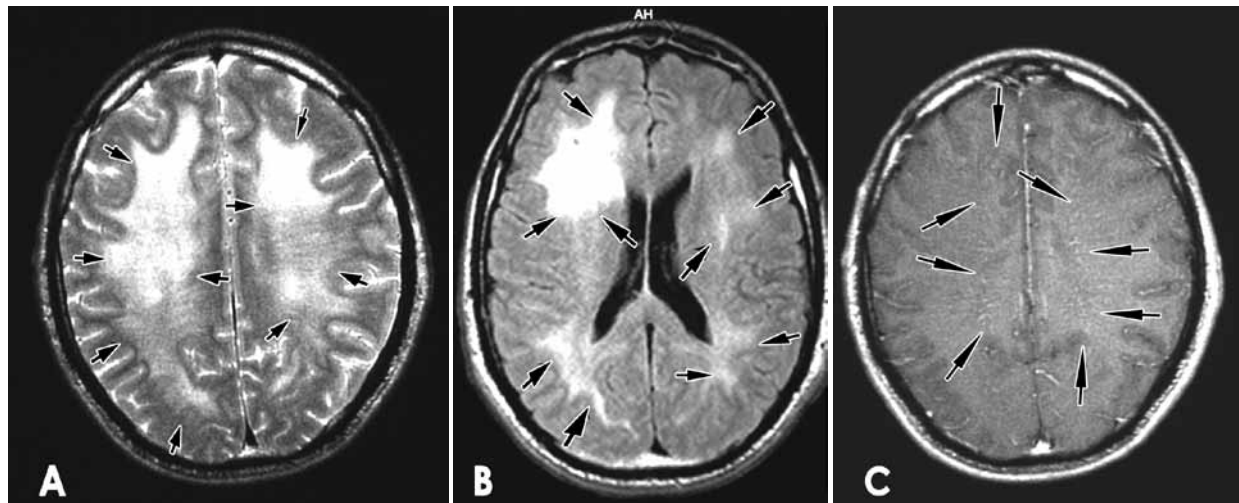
Diffuse white matter signal changes (arrows) are seen on T2 weighted A), and FLAIR sequences images B). On contrast enhanced T1 weighted image C), barely visible enhancing lines (arrows) are noted within white matter areas.
